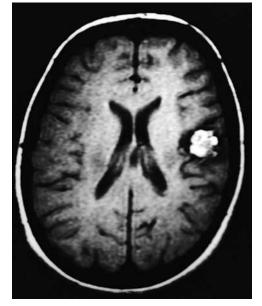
Intracranial hemorrhage. Enhanced MRI scan demonstrating a cerebral hemangioma with associated old hemorrhage. (*Courtesy Michael J. Painter, MD, Children's Hospital of Pittsburgh, Pittsburgh, Pa.*)
